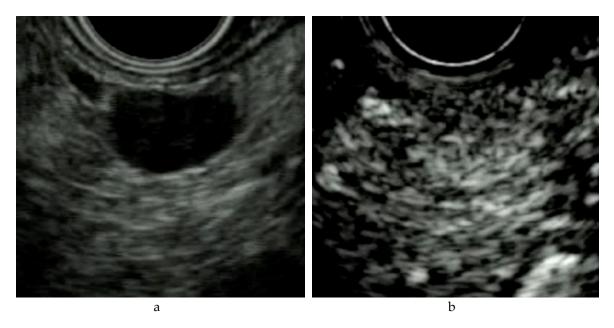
(a) B-mode endoscopic ultrasound (EUS): a circular hypoechoic mass in the body of the pancreas. (b) Contrast-enhanced EUS: the mass shows early enhancement compared with the surrounding pancreatic parenchyma.
